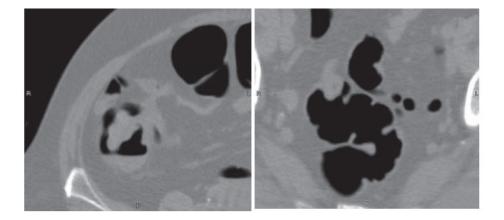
Virtual colonoscopy – a view of pediculaneted polypus and a small carcinoma - CT images.
